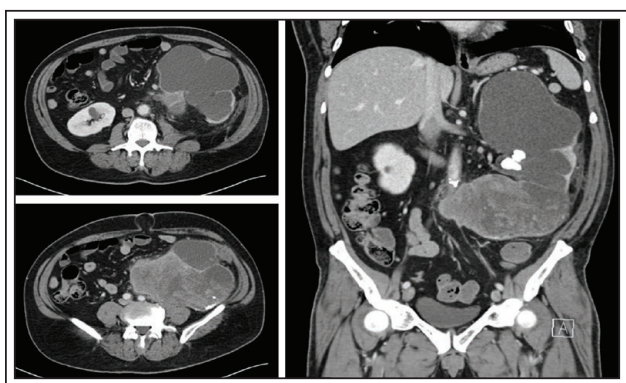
CT abdomen/pelvis with contrast demonstrating left upper pole severe chronic hydronephrosis with large calculi and a heterogenous renal mass with dystrophic calcifications occupying the mid and lower poles with expansion outside of Gerota's fascia but not invading nearby organs suspicious for possible renal malignancy.
